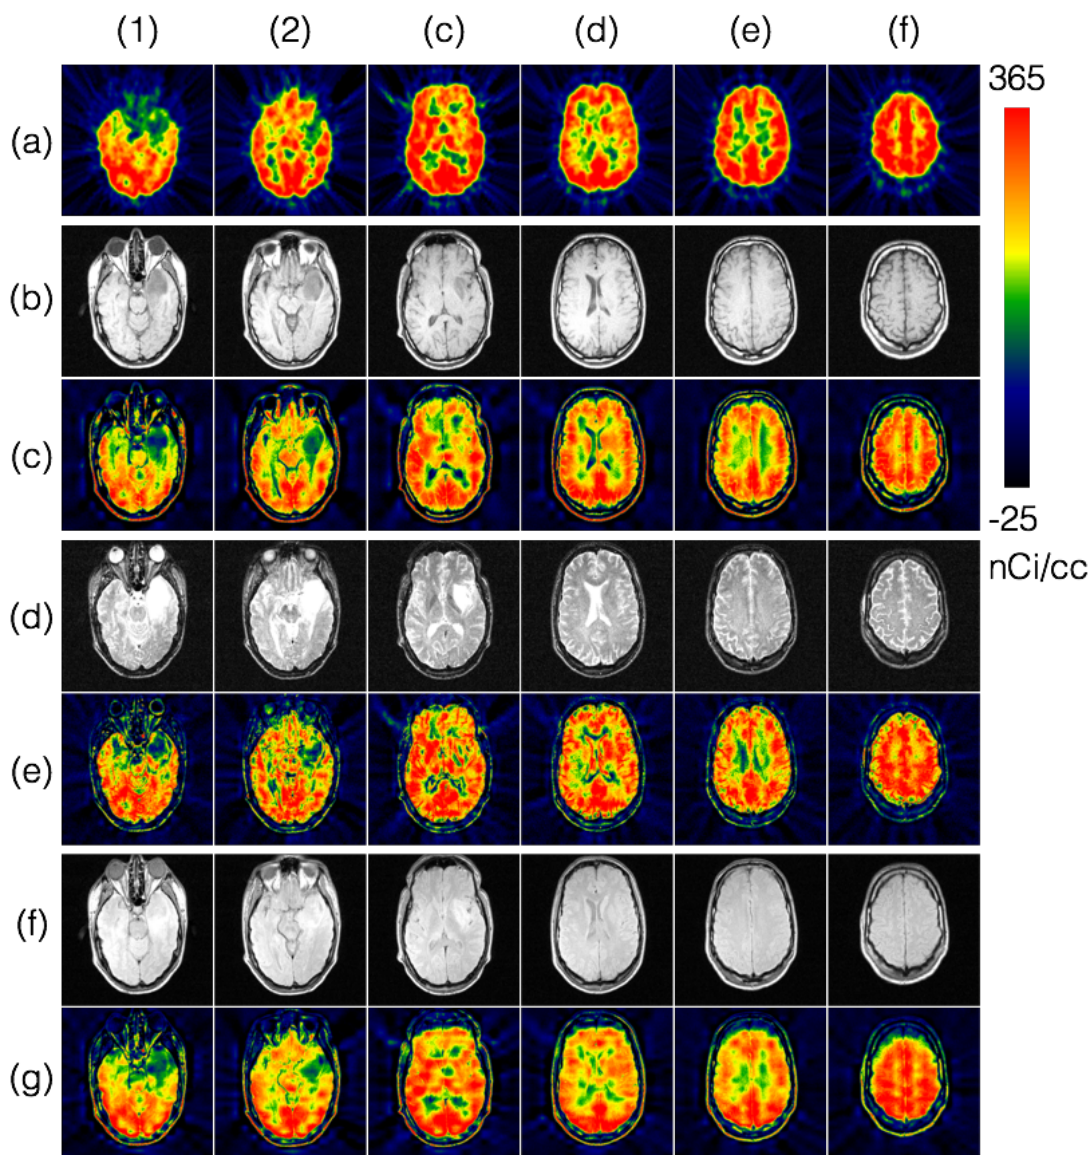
2D planes of (a) 18F-FDG PET, (b) T1, (c) T1-corrected PET, (d) T2, (e) T2-corrected PET, (f) PD, and (g) PD-corrected PET images.
